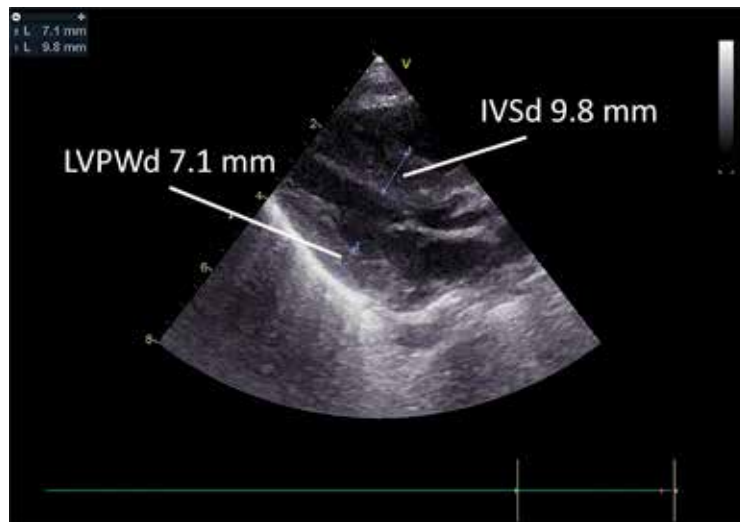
Long-axis view of the patient's echocardiography on admission. Interventricular septal thickness at end-diastole (IVSd) and left ventricular posterior wall thickness at end-diastole (LVPWd) were 9.8 and 7.1 mm, respectively. Both revealed hypertrophic changes. Asymmetric septal hypertrophy (IVSd/LVPWd = 1.38) was also noted.
